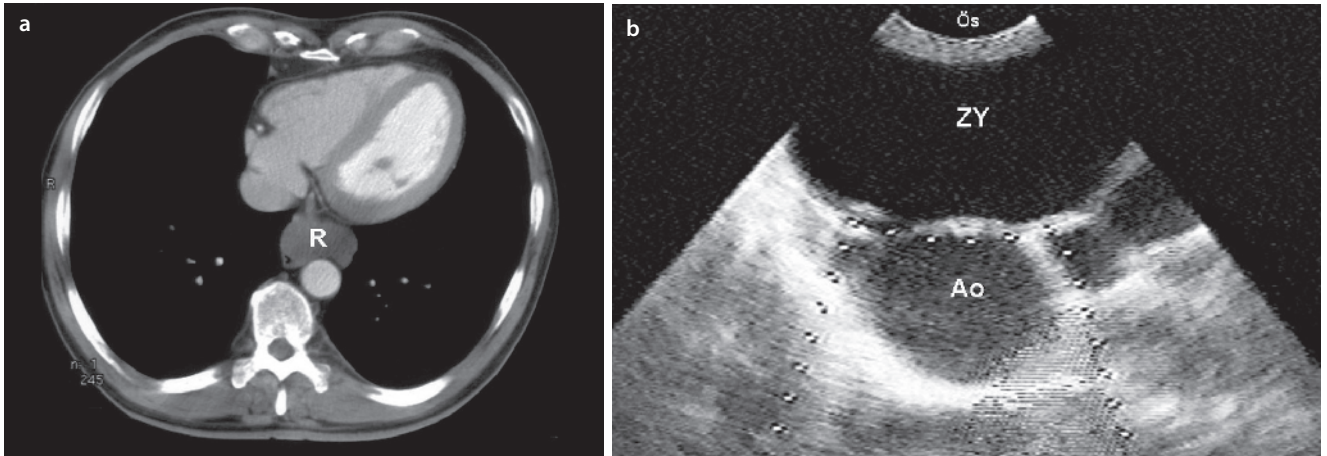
(a) Computed tomography of the thorax. Sharp well-defined lesion (R) (2 cm × 1 cm × 1 cm) located in the lower mediastinum. The heart and descending aorta are easily identified. (b) Endosonography. Remarkably echo-poor, well-demarcated, easily compressible lesion (cyst located immediately adjacent to the esophagus (Ös)) without a signal on color-Doppler sonography—sonographically compatible with a cyst. Ao aorta
